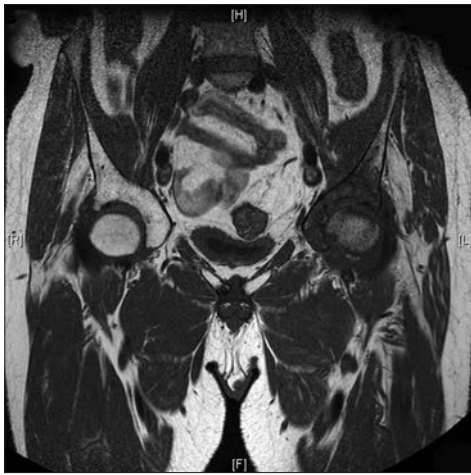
T2 weighted MRI of the Pelvis showing destruction of the left acetabulum and decreased signal in the left femoral head, with marrow oedema
